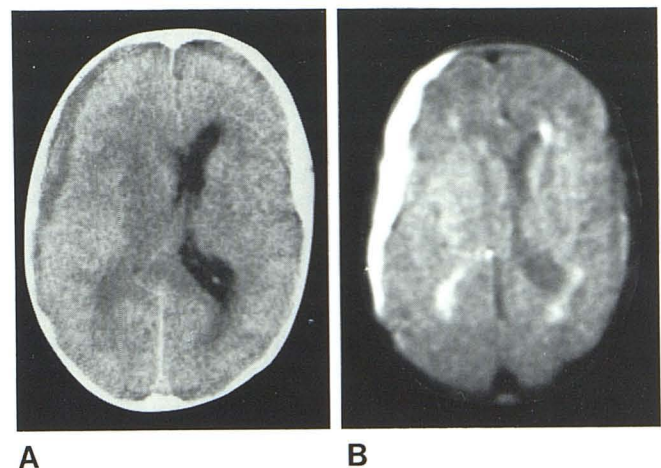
CT scan (A) and spin-echo NMR scan (B) of subdural hematoma. Collection is hypodense on CT and is better seen on NMR scan, reflecting long T_2 time of clotted blood. Periventricular edema is also known.
